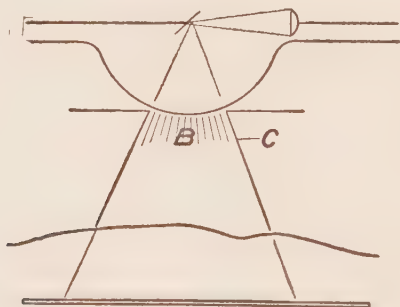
Above figure shows the same tube as Fig. 44, but having a diaphragm which cuts off all of the wild rays except the few which go through the opening, thus tending to make the negative very much more distinct. As the danger from the careless use of the X-ray is now well known and understood, every operator should take all necessary precautions to protect not only his patient, but himself. For treatment purposes, the lead glass tubes should be used, or the tube should be inclosed in a protecting shield. In addition to this, the operator should stand behind a shield lined with lead one-thirty-second of an inch in thickness.
